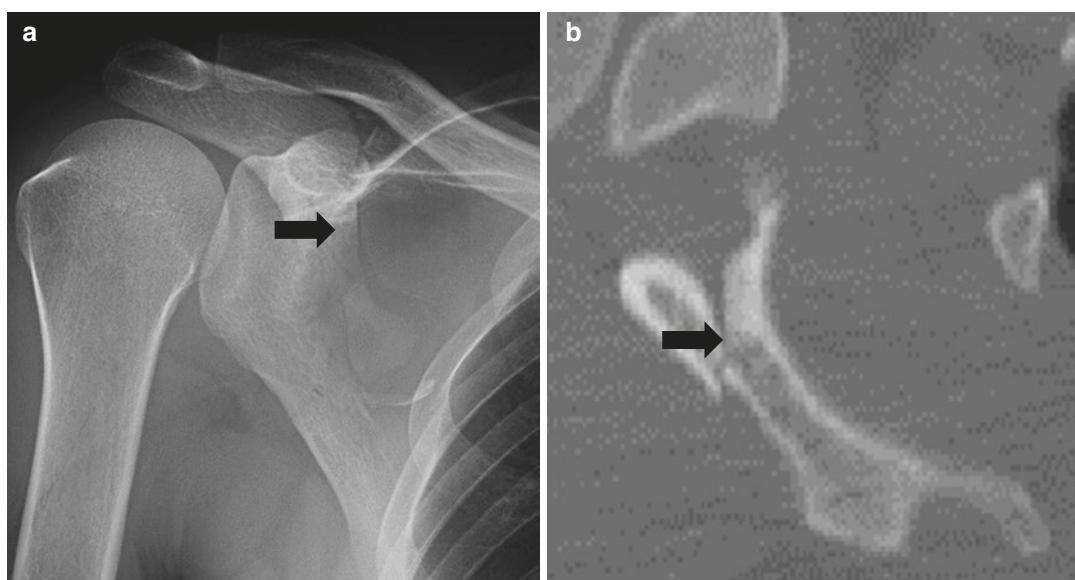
Forty six-year-old man presenting after MVC. Right shoulder radiograph (a) and Axial IV contrast-enhanced CT image of the right scapula in bone window (b) show acute right fracture through the scapular spine (arrow)
